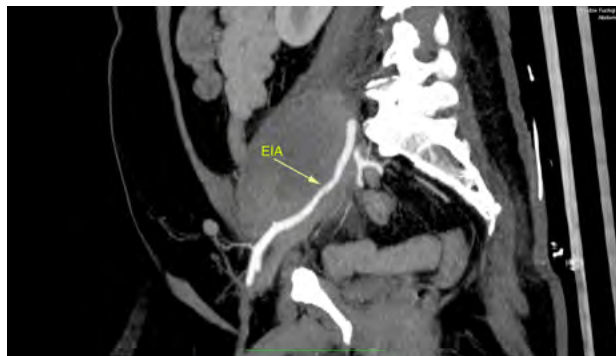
Retroperitoneal tumor associated with left external iliac artery (CT sagittal view)
